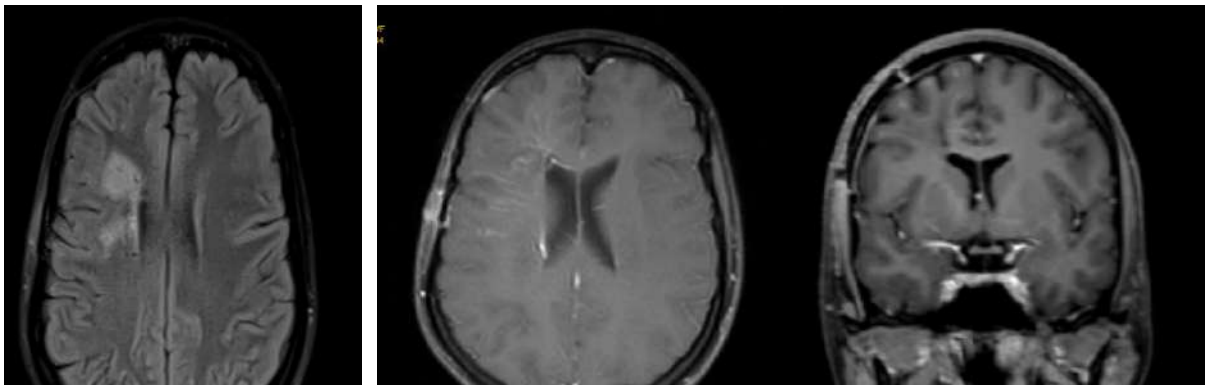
Post treatment follow up MRI suggest significant reduction in the previously mentioned T2 hyperintensities as well as reduced lepto meningeal enhancement on post-contrast study.
